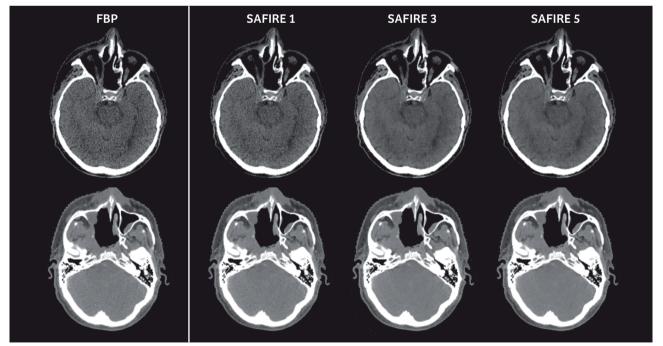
Iterative reconstruction with SAFIRE vs. reconstruction with filtered back projection in the brain and head region for both planning CT (top) and control CT (bottom). Three different SAFIRE filter levels have been tested. All CT images are reconstructed from a DECT scan as a pseudo-monoenergetic CT at 50 keV using *syngo*.via MonoenergeticPlus.
